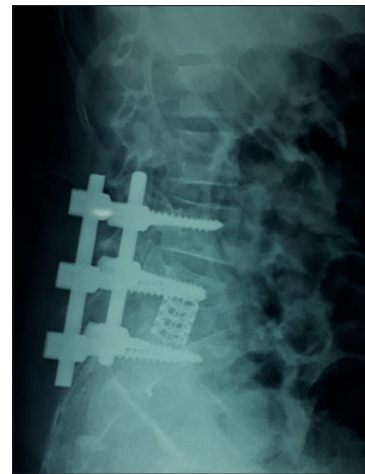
Postoperative X-ray showing the pedicle screw.
